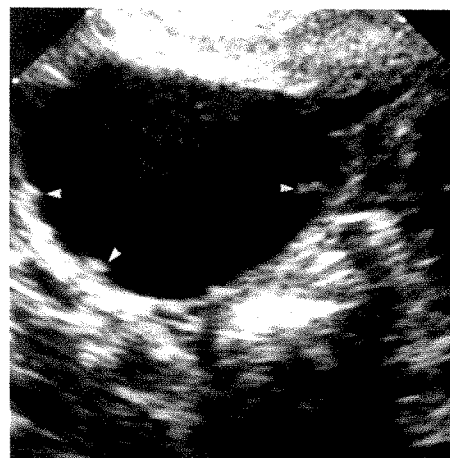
Transverse endovaginal sonogram of right adnexal region shows a fluid-filled structure with short, linear echoes protruding into lumen (arrowheads). Dilated fallopian tube was seen at laparoscopy.
